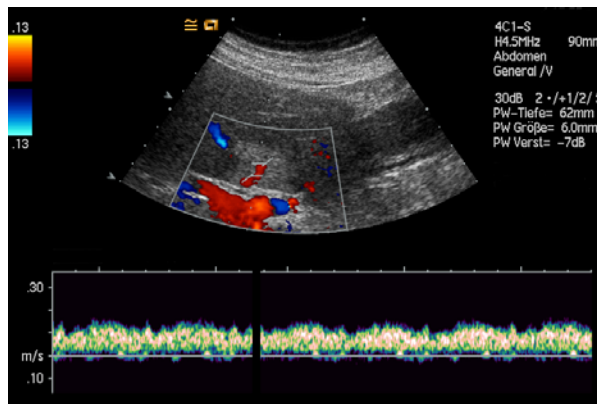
Hepatic steatosis indicated by focal hyperechoic ([28]) areas in the liver hilum. They are characterised by centrally located (portal) vein branches identified by colour Doppler imaging (a), spectral analysis and CEUS (b). Such lesions are also typically found subcapsular next to the teres ligament [28].
